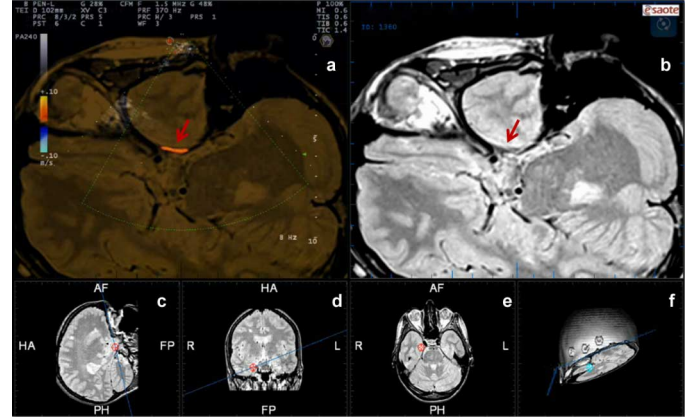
Example of superior petrosal sinus insonation ipsilateral to the probe. (a) US fused with MRI; (b) MRI oblique plane; the vessel position is confirmed by the marker visualized on sagittal (c), coronal (d) and axial (e) views; (f) cut MRI rendering corresponding to the current US insonation plane.
